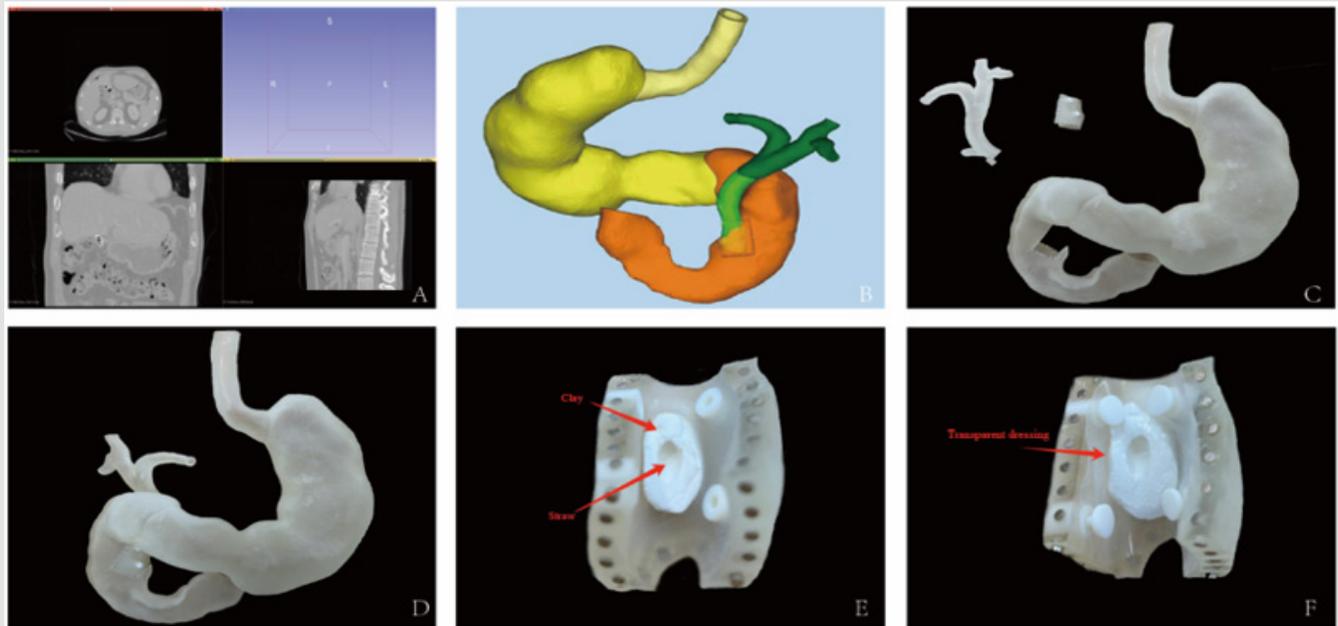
Construction of a 3D-printed model on the basis of CT data.
